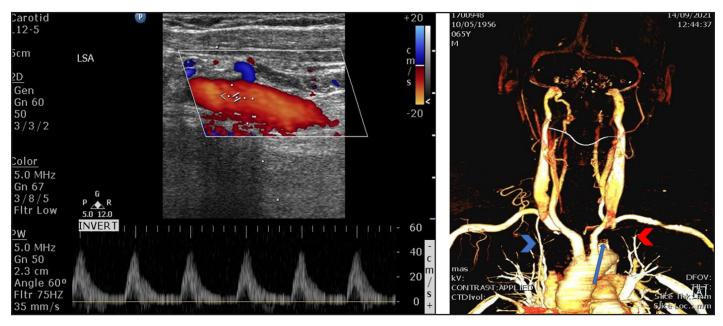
Left side: CDUS of the left SCA shows low upstroke waveforms (tardus parvus with peak systolic velocities of ~40 cm/s). Right side: CT angiogram of the carotids; proximal left SCA occlusion is demarcated by a blue arrow. Right ITA is visible (blue chevron) while the LITA is not depicted (red chevron). CDUS: color Doppler ultrasonography, SCA: subclavian artery, ITA: internal thoracic artery, LITA: left internal thoracic artery
